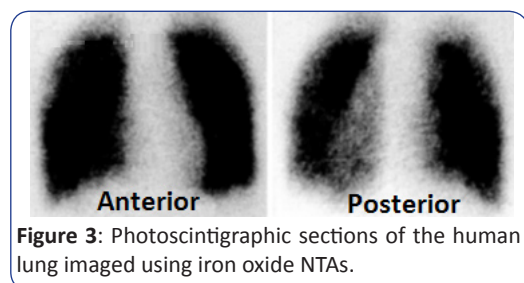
Photoscintigraphic sections of the human lung imaged using iron oxide NTAs.
